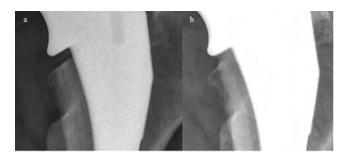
to 1B. (1A) Calcar Gap evident on immediate postoperative radiograph, (1B) Osseointegration with filling in of the Calcar gap and osseointegration in Gruen zone 7 by one-year postoperatively.
